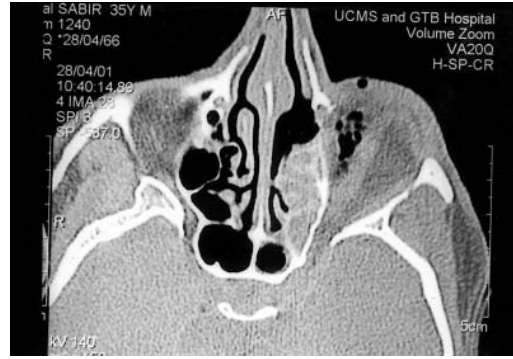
Axial CT-scan showing marked thickening of the mucosa of the left ethmoidal sinuses.
